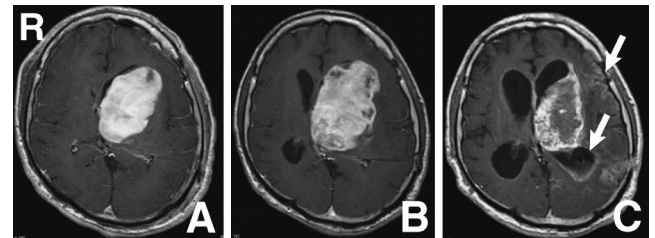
Serial T₁-weighted magnetic resonance images with gadolinium after tumor biopsy and ventriculoperitoneal shunt (A) and 5 months after tumor biopsy (B) showing enlargement and heterogeneous enhancement of the tumor, and 17 months later (C) showing dissemination of the tumor to the ventricular wall and brain surface (arrows) and marked hydrocephalus.
